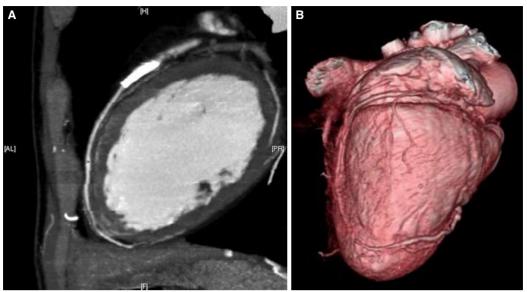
The course of the left anterior descending coronary artery by (A) multislice CT angiography and (B) three-dimensional volume rendered reconstruction.
